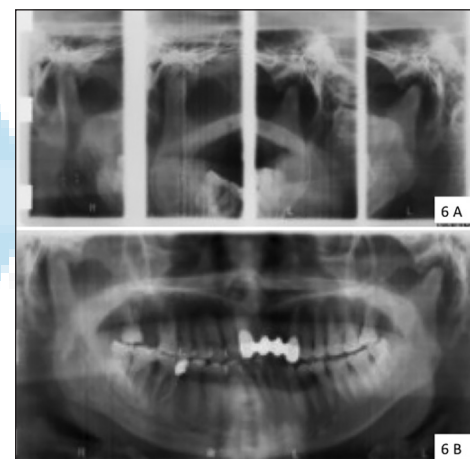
(a) Plain radiography of the temporomandibular joint revealed the absence of erosion and full mobility bilaterally in the condylar head of the mandible after two years. (b) On panoramic radiographs, the cortical surface of the left mandibular condylar head is smooth
